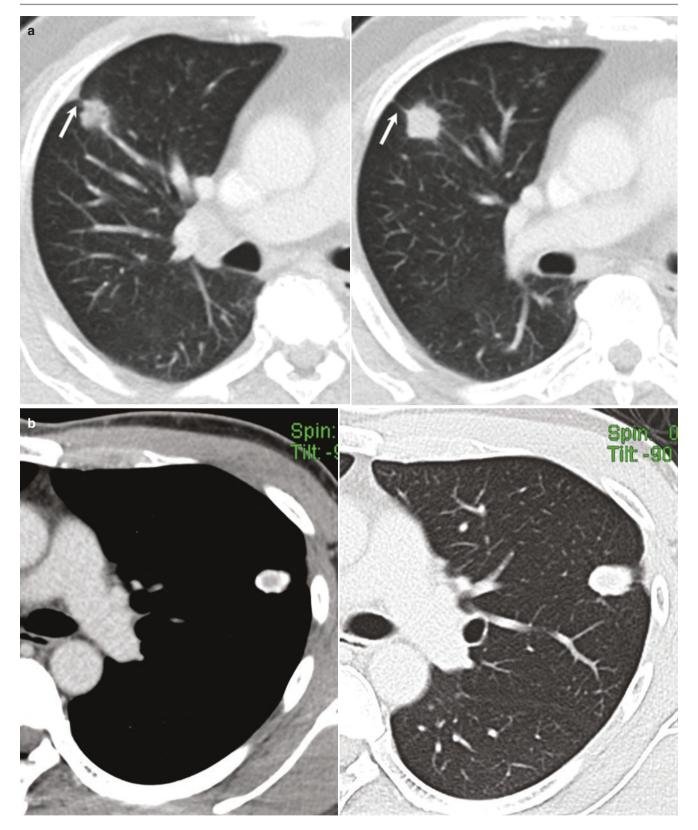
Pleural tag. Adenocarcinoma. (a) Axial CT images show a linear or band-like opacity between a peripherally located mass and adjacent pleura (arrow). Tuberculoma. (b) Multiple pleural tags in peripherally calcified nodule
